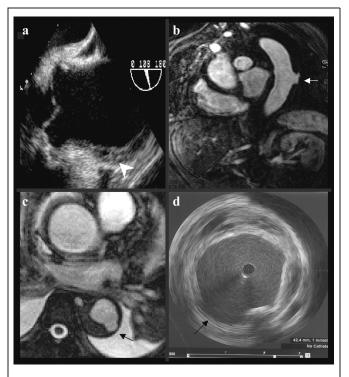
The ascending aorta by TEE showing thickened wall, identified by the arrowhead (A); contrast MRI of the descending aorta revealing extravasation into the penetrating ulcer as identified by the small arrow (B, C); and IVUS at the site of the penetrating ulcer as shown by the small arrow (D).
